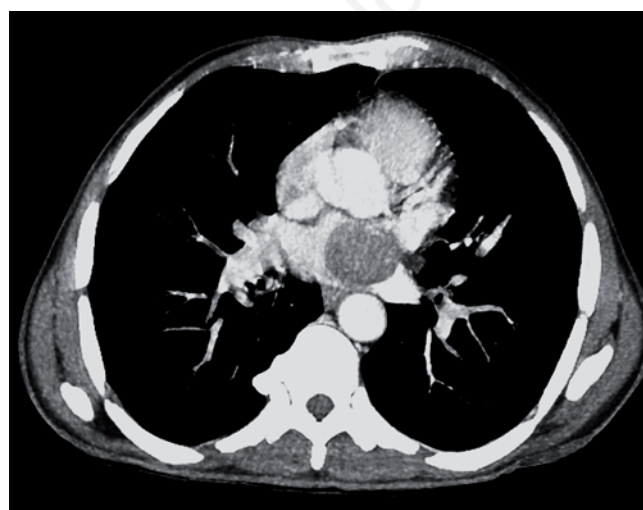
Chest CT scan. Pulmonary neoplasm extended in the left atrium through the pulmonary vein.
